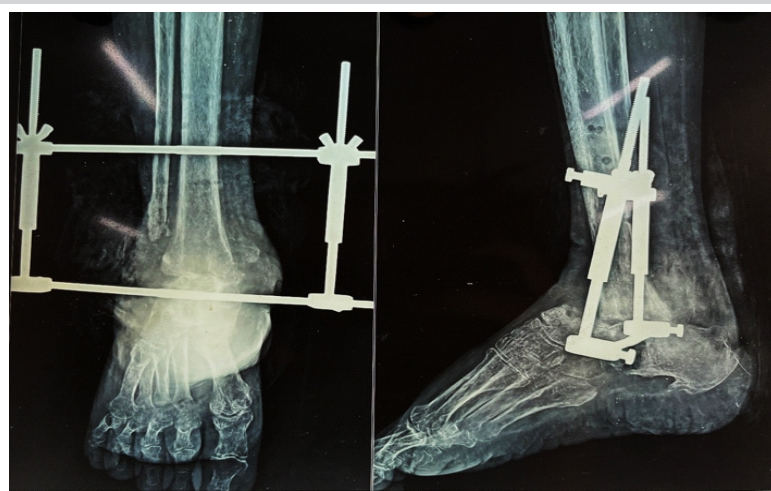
Anteroposterior and lateral radiographs of the right ankle showing Charnley compression arthrodesis with external fixator in situ and absence of radiological fusion at the ankle joint.
